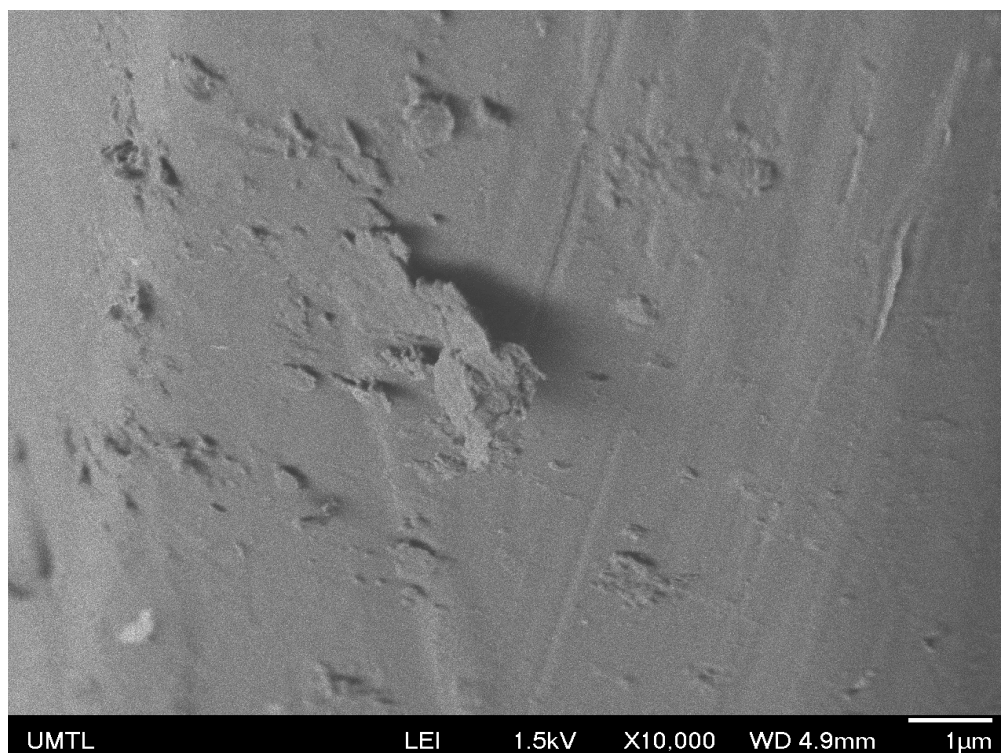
SEM images of Cu⁰/H2O-CT.
